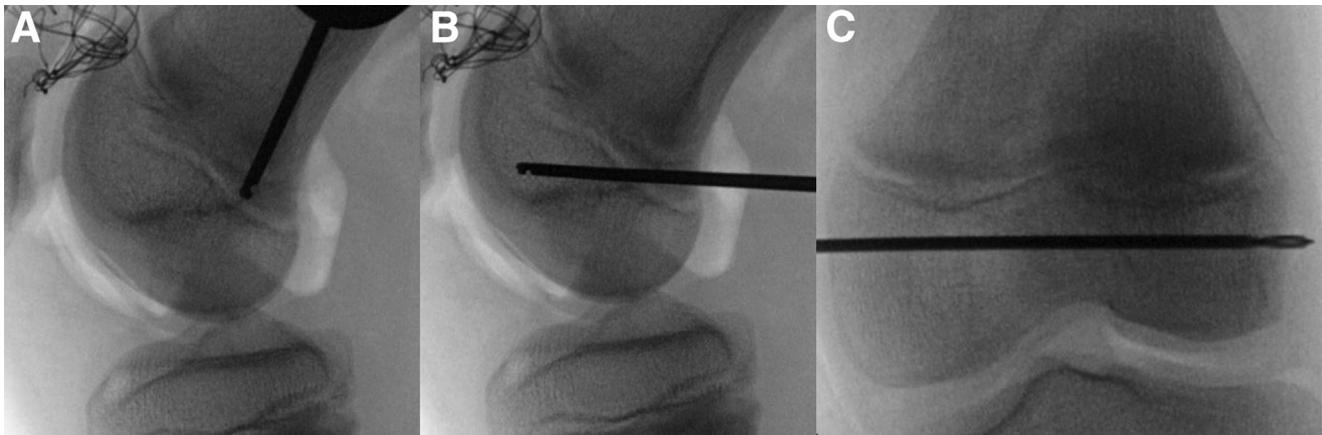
Intraoperative fluoroscopy of a right knee. In all skeletally immature patients, the drill was started at Schöttle's point as visualized on lateral radiograph (A). The drill was aimed distally into the epiphysis to avoid crossing the physis. Trajectory for femoral tunnel placement is demonstrated on lateral (B) and anteroposterior (C) radiographs.
